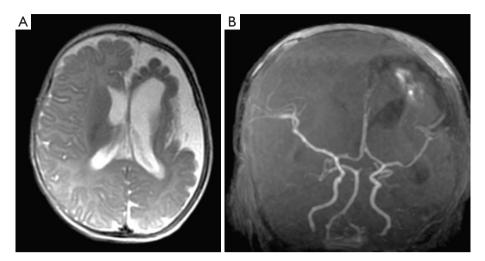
Patient 2 (*Table 1*): T2-weighted axial magnetic resonance image of the brain (A) showing atrophy of the left hemisphere with dilatation of the left ventricle and cortical dysplasia; magnetic resonance angiography of the brain (B) shows reduction in calibre of the left cerebral artery (especially the Sylvian artery).
